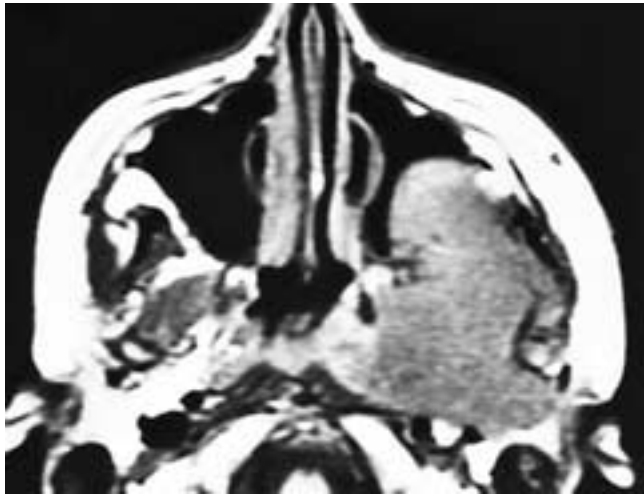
Axial T1-weighted MR image shows a homogeneous mass in the left infratemporal fossa extending into the left antrum and the skull base. The mass has an intermediate signal intensity. This patient had a rhabdomyosarcoma.
